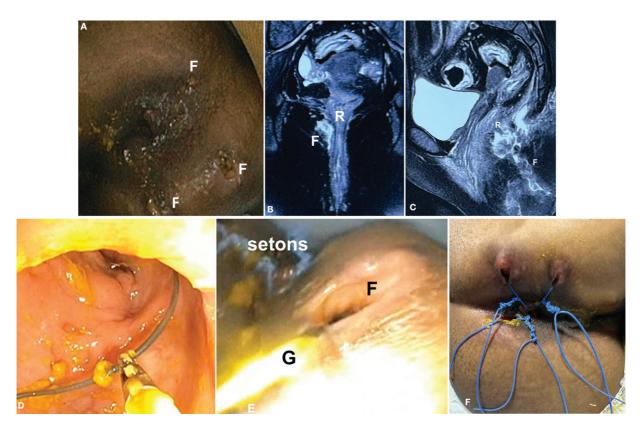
(A) Complex perianal fistula with feculent discharge, (B) axial magnetic resonance imaging (MRI) showing right intersphincteric fistula (F) draining into rectum (R), (C) MRI sagittal section showing presacral extension of fistula tract. (D) Jagwire (Boston Scientific) introduced into rectum through external opening of left-sided fistula seen on colonoscopy, (E) guidewire (G) placed inside fistula cavity through large external openings of right-sided fistula (F) using ultra-thin endoscope. F. Postprocedure after complete placement of all setons across fistula tract.
